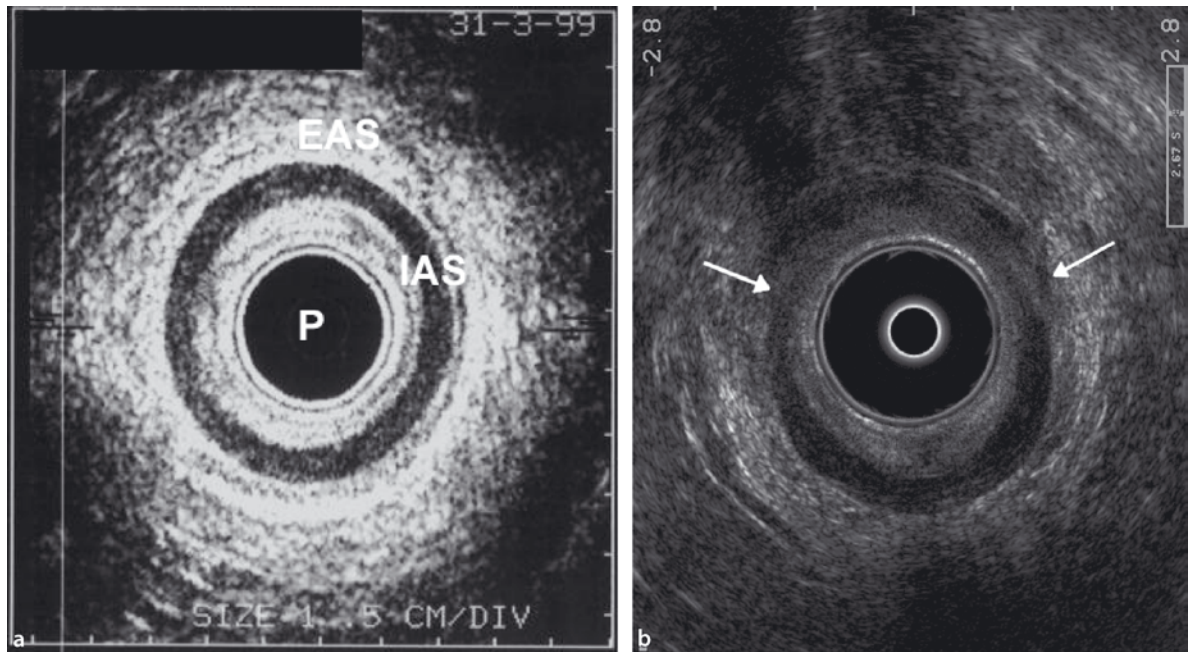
Transanal ultrasonography. a Intact internal anal sphincter muscle (IAS) and external anal sphincter muscle (EAS). The central dark spot is the probe (P). b Anterior lesion (arrows) of the internal and external anal sphincter muscles (bottom)
